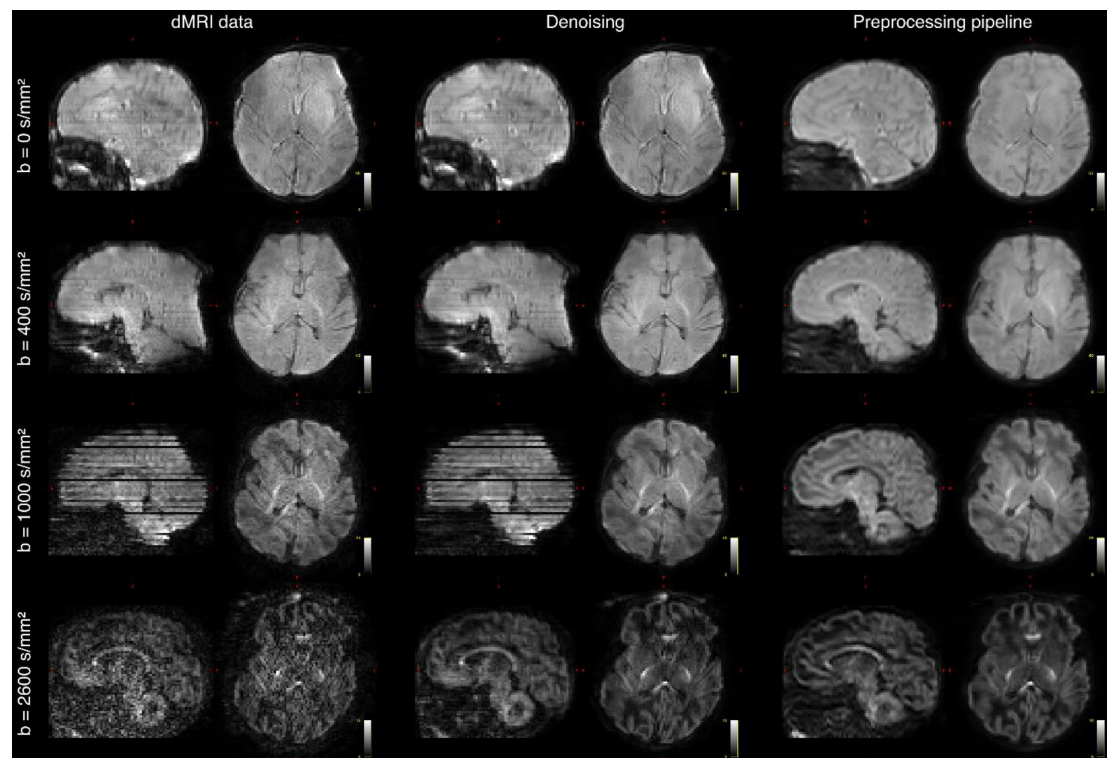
Diffusion MRI (dMRI) data from the same infant. Shown are four selected volumes with different b -values and phase encoding directions. Left: input data after MB-SENSE reconstruction. Middle: images after denoising. Right: images after motion and distortion correction and destriping.
